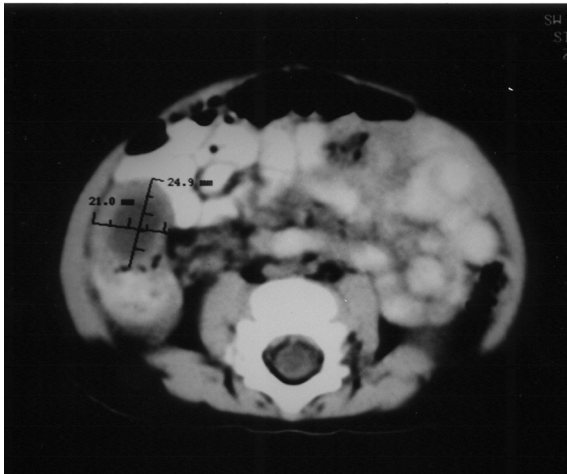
Axial CT scan of the abdomen, demonstrating a well-circumscribed oval fluid lesion adjacent to the cecum and measuring 2.1x2.5 cm.
